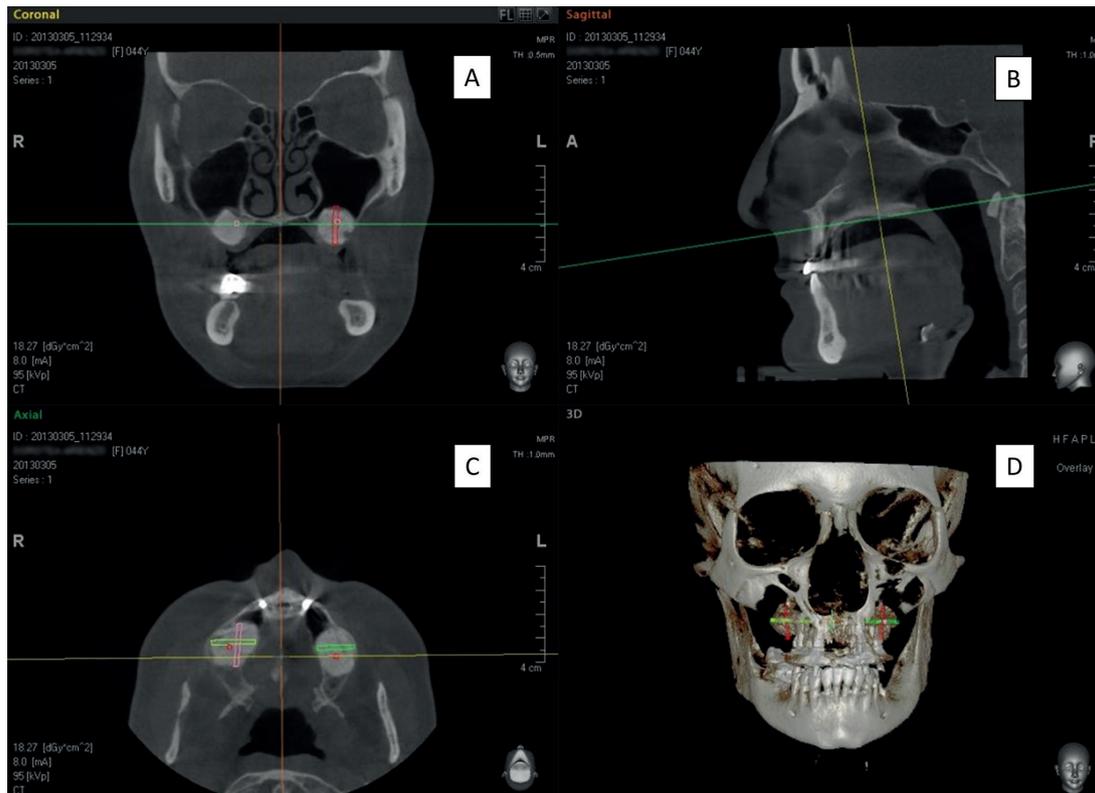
CT images of the maxillary sinus after regenerative procedure. A, coronal projection, (B) sagittal projection, (C) axial projection, (D) 3D reconstruction.
